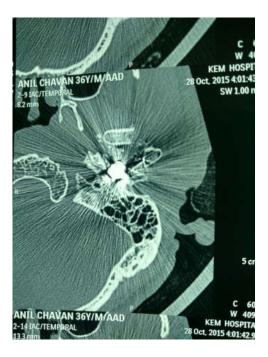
CT Scan showing Bullet in Infratemporal fossa
